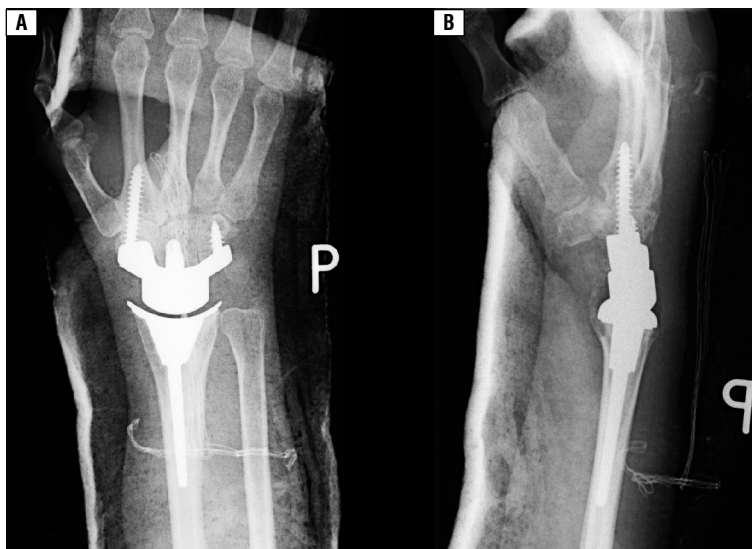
Post-operative X-ray of right wrist 19 January 2009: A. Anterior-posterior; B. Lateral
